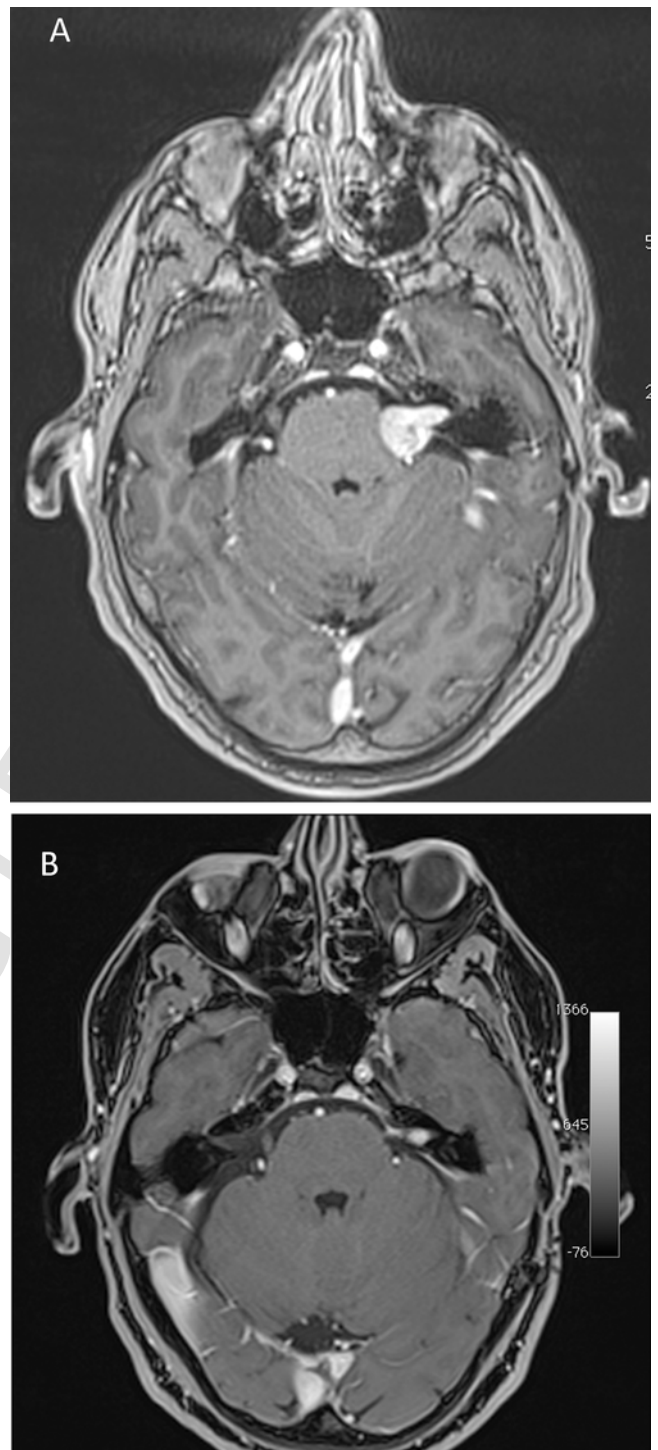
(a) T1-weighted axial MRI with contrast medium: hyperintense VS arising from IAC; maximum diameter 2,2cm. (b) 6-month postoperative axial MRI on T1 after contrast medium injection; near total removal of tumor (small residual of capsule in the IAC). Postoperative hearing: Class B (unchanged).
